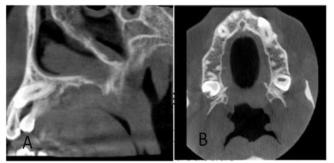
(A & B). Coronal and axial view of CBCT show root resorption in cervical surface of adjacent tooth
